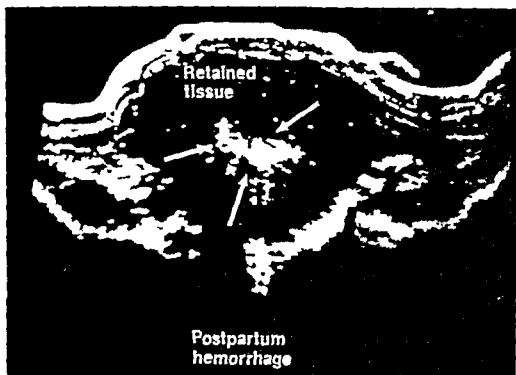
8 Postpartum hemorrhage Retained tissue demonstrated on sonogram
